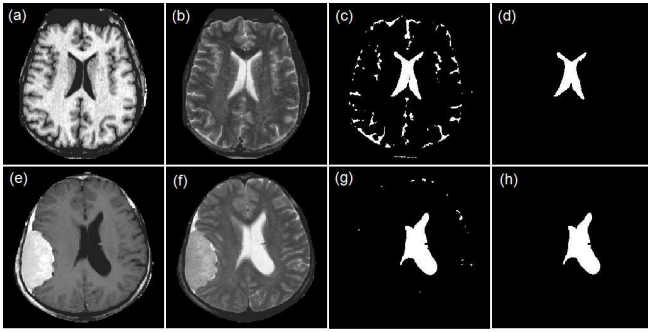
Lateral ventricular shape retrieval results: (a) healthy T1-weighted MR image data; (b) T2-weighted MR image data of (a); (c) after tissue segmentation on (a) and (b); (d) extracted lateral ventricles from (c); (e) tumor-affected T1-weighted MR image data; (f) T2-weighted MR image data of (e); (g) after tissue segmentation on (e) and (f); (h) extracted lateral ventricles from (g).
